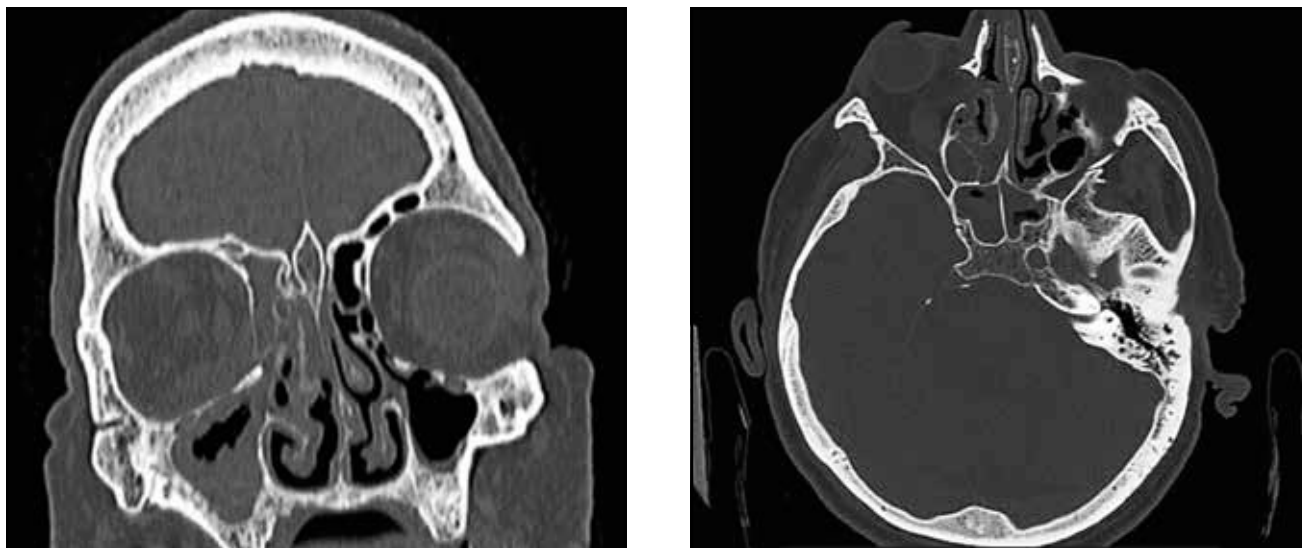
Coronal and axial view of preoperative CT scan – obliteration of right-side maxillary, frontal, ethmoid, sphenoid sinuses with bone erosions and extension of the disease into the retro-orbital space, with soft-tissue thickening at the level of the orbital apex.
